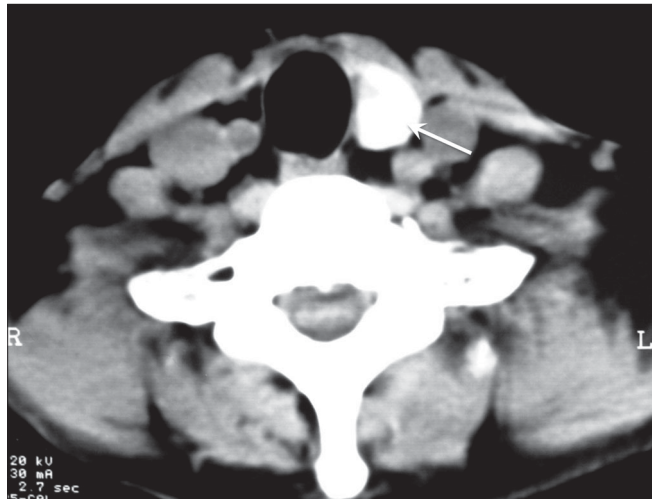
CT scan of the neck shows absence of the right lobe of the thyroid. The left lobe is well seen (arrow)
